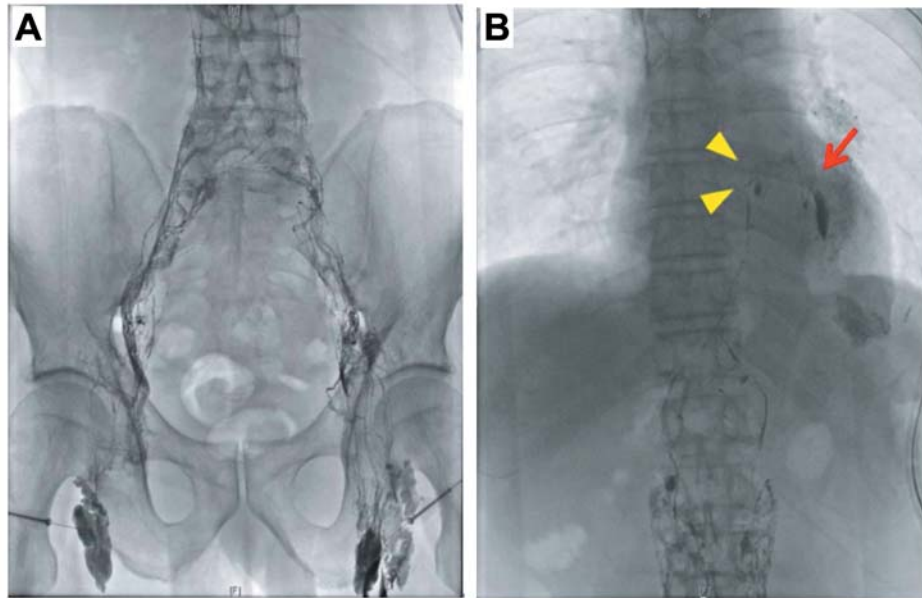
Spot radiograph of the bilateral groin nodes shows the initial phase of intranodal injection of lipiodol with opacification of the bilateral inguinal lymph nodes (A). Spot radiograph obtained 30 min after starting the injection shows clips (arrowhead) and a leakage (arrow) of lipiodol to the left thoracic cavity at the level of the lower mediastinum (B).
